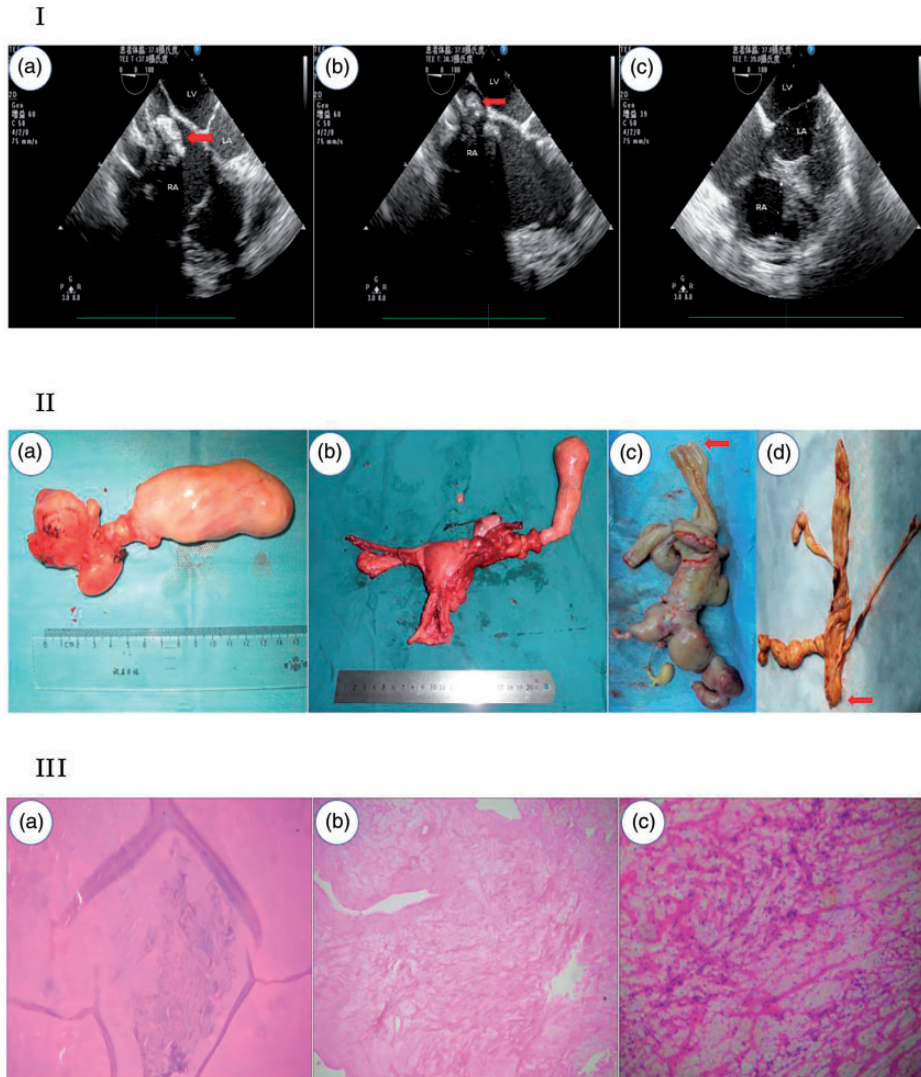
(I) Intraoperative transesophageal echocardiography showing changes in the intracardiac mass before and after resection. (II) Removal of mass, uterus, and bilateral uterine attachments. (c), (d) Red arrows point to the distal extremity mass and the proximal cardiac mass resected under the renal vein. (III) Intraoperative frozen and postoperative pathology.
